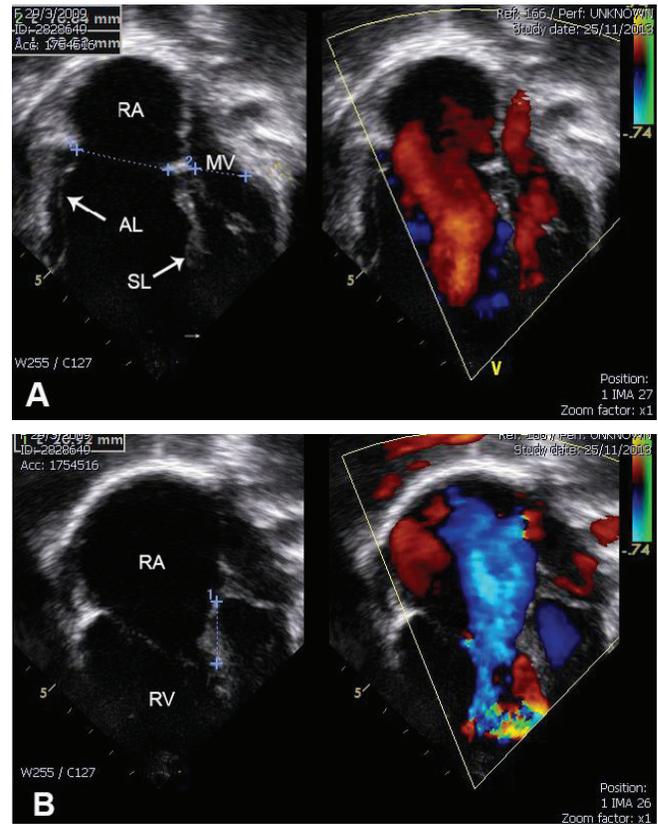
Echocardiogram of an Ebstein's anomaly patient showing: severe displacement of the septal leaflet of tricuspid valve, dilation of the right atrium, and right ventricle. The color flow Doppler reveals good blood inflow in diastole (A) and severe tricuspid regurgitation in systole (B). AL = anterior leaflet. SL = septal leaflet, RA = right atrium, RV = right ventricle, and MV = mitral valve.
